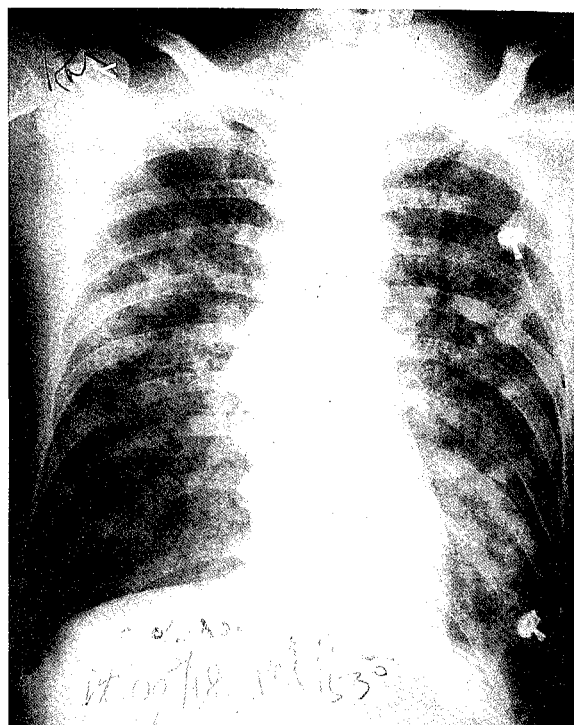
Chest radiograph reveals extensive generalized dense alveolar opacities bilaterally.
